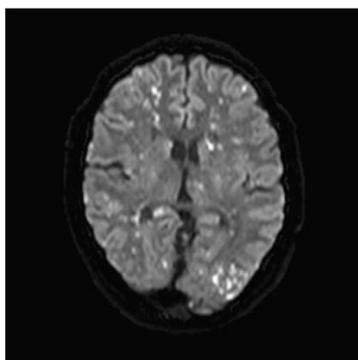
MRI Imaging. Multiple punctate haemorrhages in the brain due to FES.
